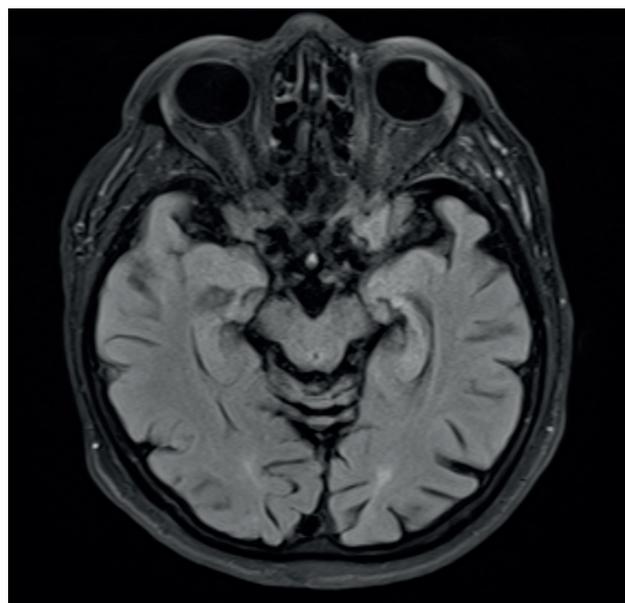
MRI with spindle-shaped lesion in the superior temporal quadrant of the left bulb
